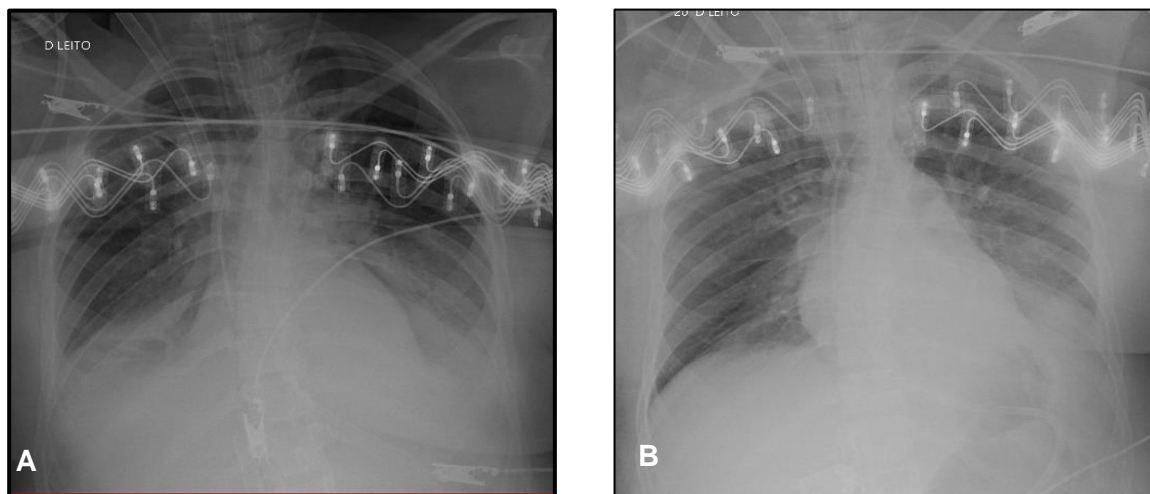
A – Chest X-ray before bronchoscopy
